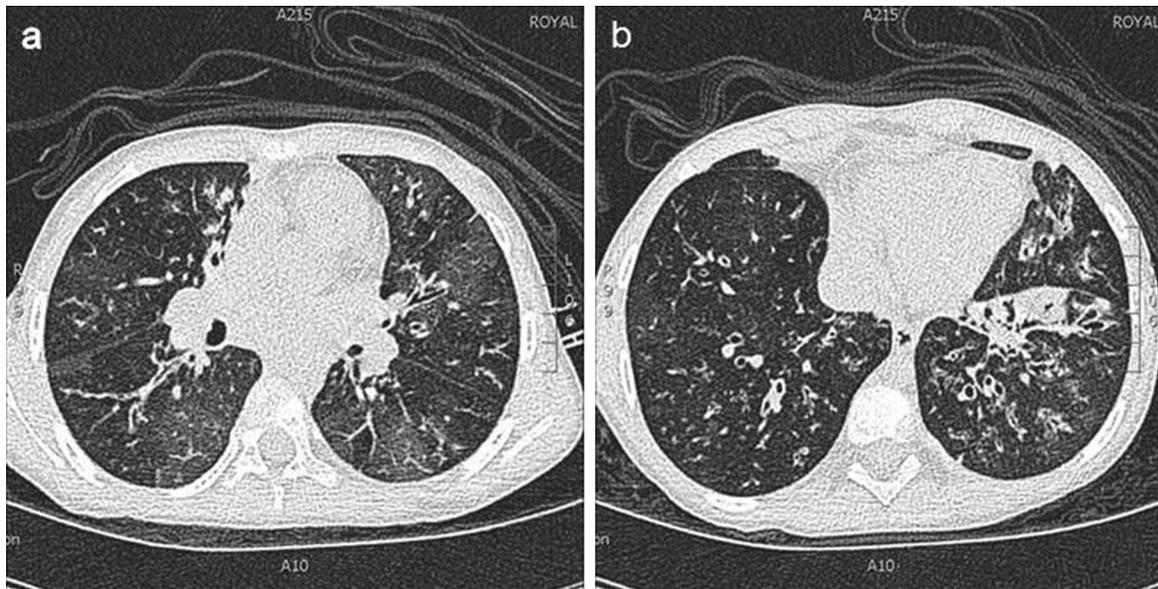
Chest CT images from a scan performed 9 months before the gastrostomy insertion, showing (a) mosaicism suggestive of severe small airways disease, and (b) dilated airways consistent with bronchiectasis.
